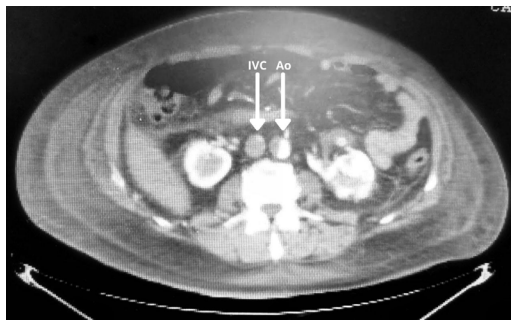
Contrast abdominal CT showing 50% occlusion of abdominal aorta below the renal arteries. IVC: inferior vena cava, Ao: Aorta.
